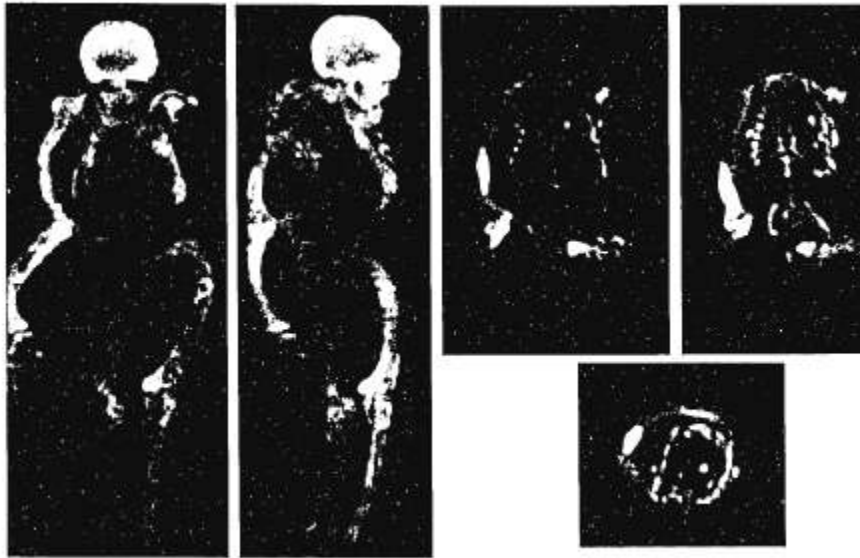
[^{18}F]Fluoride ion whole body projection images (left), coronal images (top right), and transaxial images (bottom right) of a patient with polyostotic fibrous dysplasia who had a left arm amputation for degeneration of an osteogenic sarcoma in the left arm several years ago. The patient was being evaluated for lung nodules seen on X-ray CT. The whole body images show a grossly deformed skeletal system, and the increased [^{18}F]fluoride ion uptake in the pulmonary nodules (arrows) is highly suspicious for metastatic osteogenic sarcoma, which was later confirmed by biopsy.
